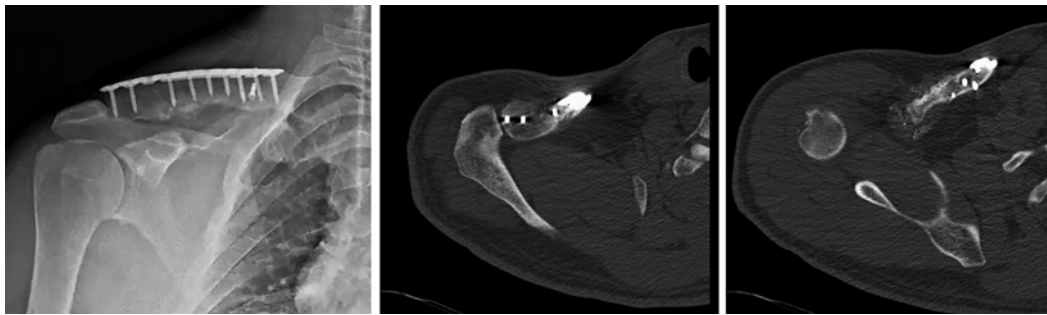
Radiographs and CT scan at 2-year follow-up.
